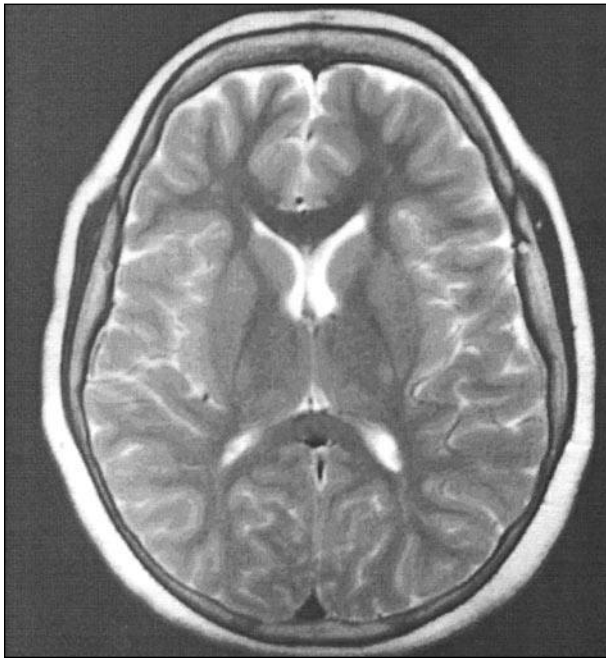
MRI brain T2 axial image showing normal signal intensity
